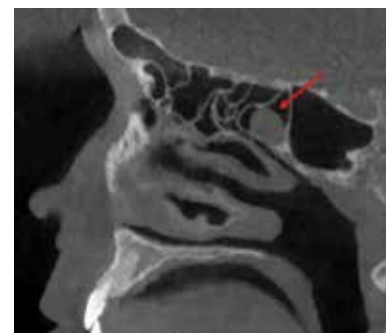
Sagittal section of CBCT, showing a cyst or polypoid formation in the posterior ethmoid sinus (red arrow).
